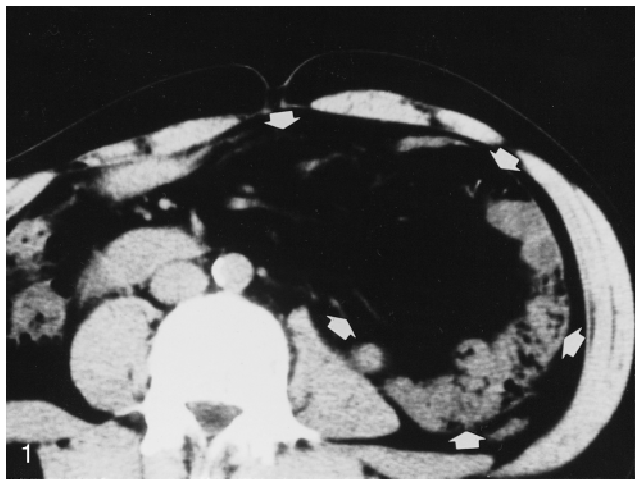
Computed tomography demonstrating a mass of intestinal loops covered by a thin capsule (arrows) on the left of the abdomen.
